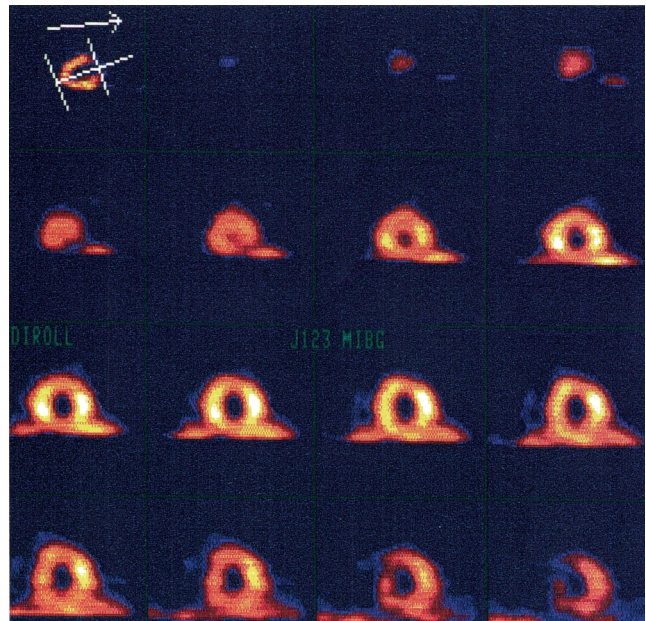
Example of a normal MIBG-SPECT. Slices taken at right angles to and along the heart axis from the apex towards the heart base – showing homogeneous tracer uptake, circular structure: left ventricle.
